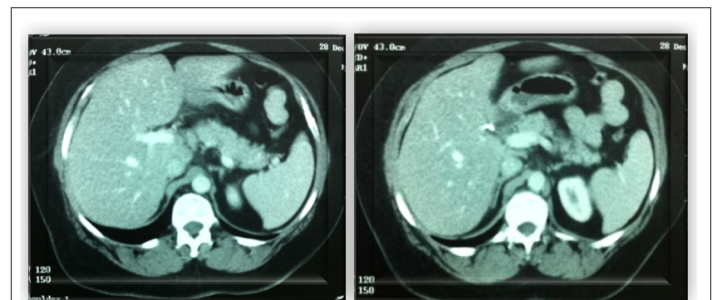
Follow-up computed tomography scan showing disappearance of hepatic lesions after six months of treatment.
